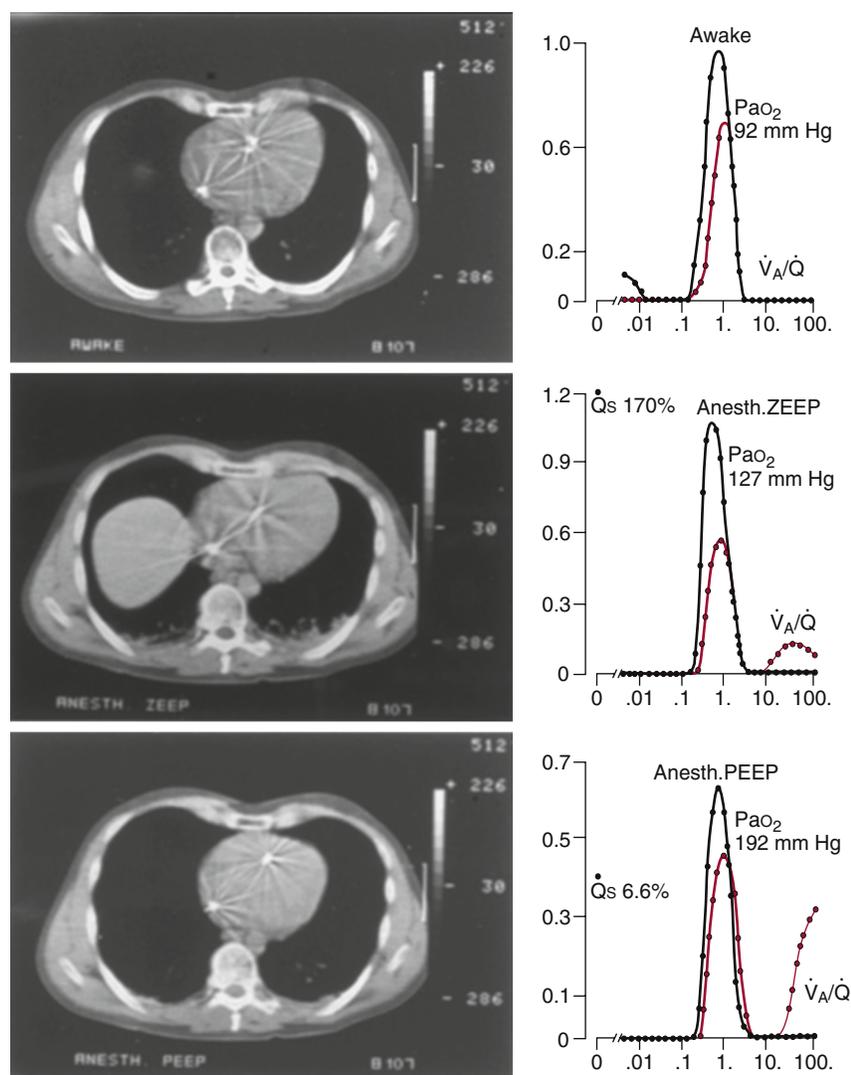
Computed tomographic scans and \dot{V}_A/\dot{Q} distributions in the lung of a healthy, awake subject during anesthesia (zero positive end-expiratory pressure [ZEEP]) and during anesthesia (10 cm H_2O positive end-expiratory pressure [PEEP]). In the awake state, there is no atelectasis and the corresponding minor low \dot{V}_A/\dot{Q} distribution (left side of plot) may reflect intermittent airway closure. During anesthesia with ZEEP, atelectasis is apparent in the lung bases (and the diaphragm has been pushed cranially). The low \dot{V}_A/\dot{Q} has been replaced by atelectasis and large shunt; in addition, a small “high” \dot{V}_A/\dot{Q} mode (right side of plot) may reflect alveolar dead space in upper lung regions. With the addition of PEEP during anesthesia, the collapsed lung tissue has been recruited and the shunt has been reduced considerably. Moreover, the “high” \dot{V}_A/\dot{Q} mode (right side of plot) has significantly increased; this may reflect additional inflation of nonperfused upper lung.
